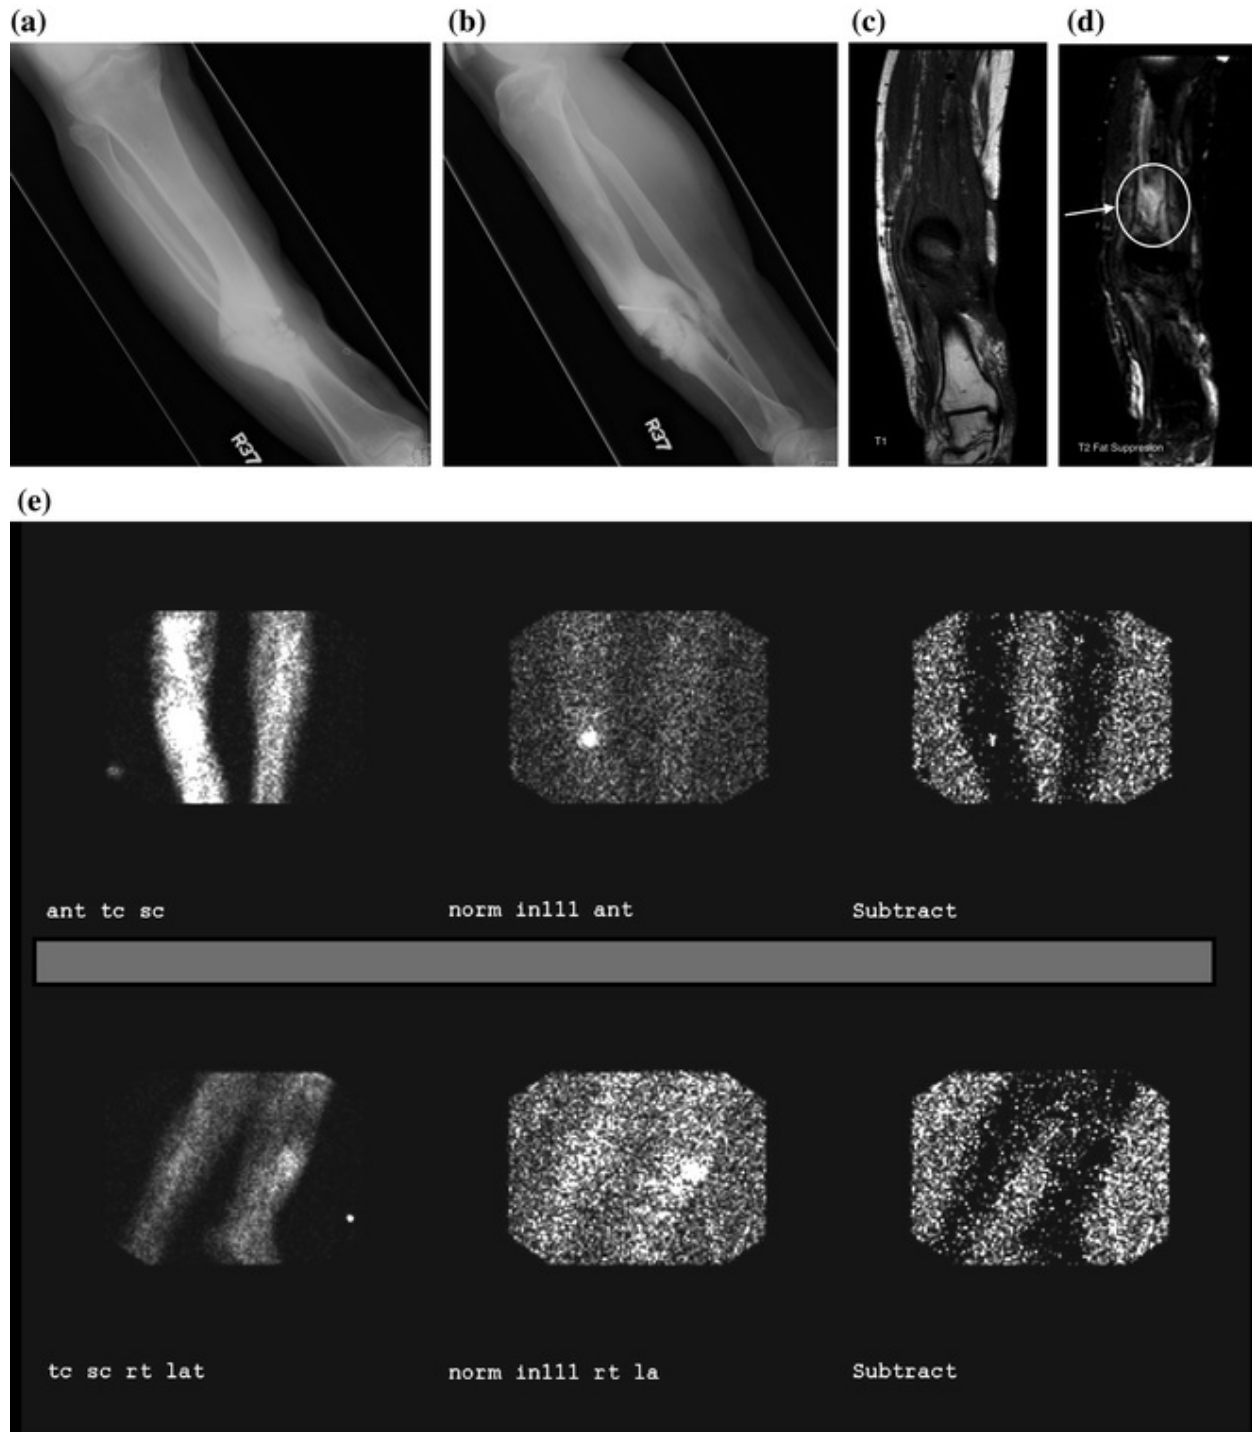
a, b Anteroposterior and lateral radiographs of patient with infected nonunion of right tibia. c, d Magnetic resonance images of tibia showing increased signal on T2 image indicating osteomyelitis. e Nuclear medicine studies showing increased uptake on indium study suggesting the presence of infection
